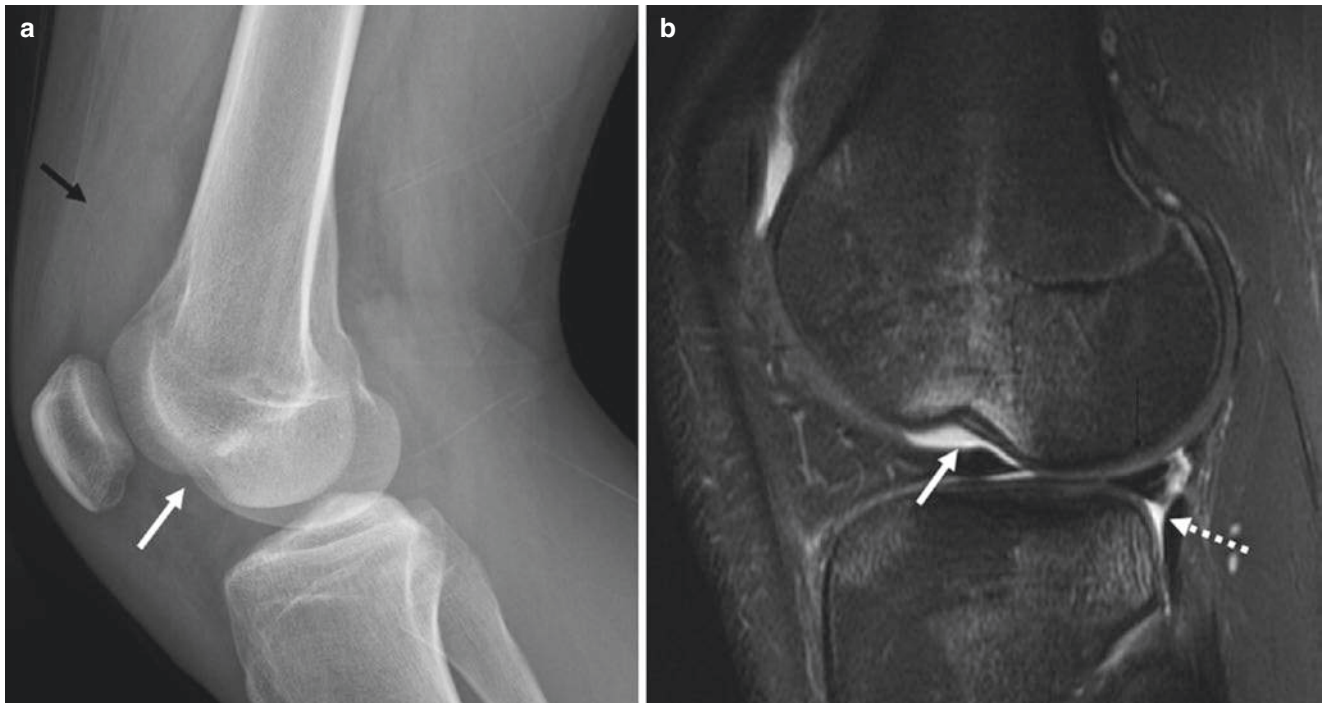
(a) Lateral view of the knee following an acute valgus injury to the knee demonstrates a deep condylopatellar sulcus consistent with an impactation injury related to ACL tear (*white arrow*). There is a large suprapatellar effusion (*black arrow*). (b) The corresponding sagittal fat suppressed T2-weighted image shows many of the secondary signs
